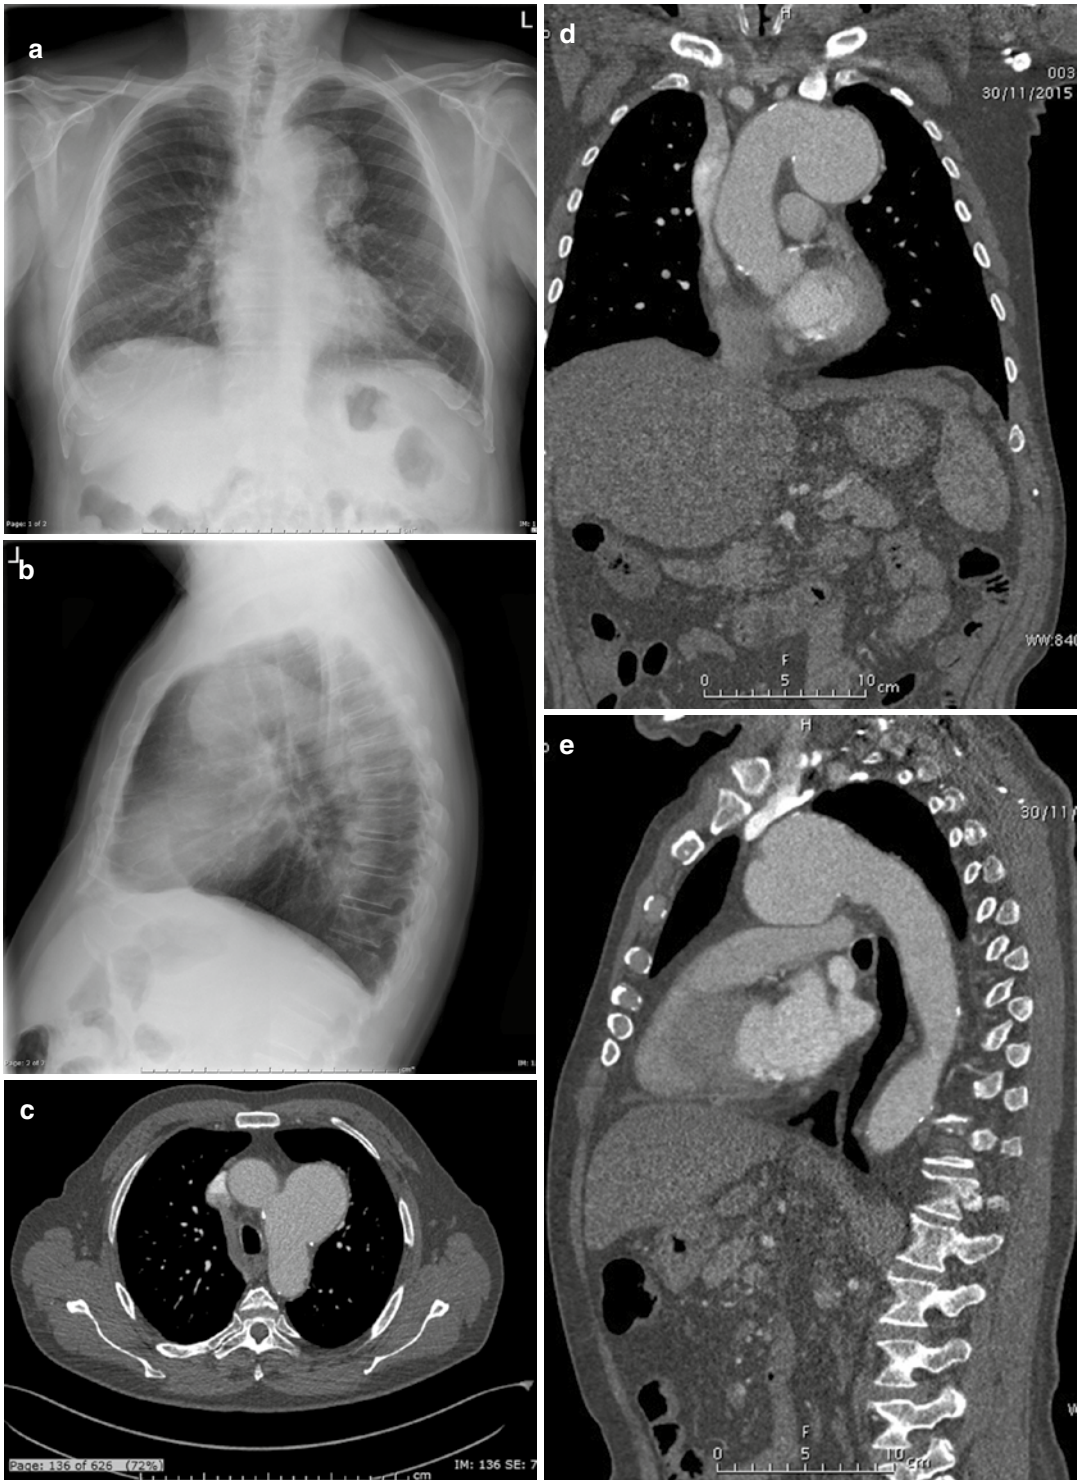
PA and lateral X-rays (a, b) show widened mediastinum, opacification of the aortopulmonary window, and rightward deviation of the trachea. Axial (c), coronal
